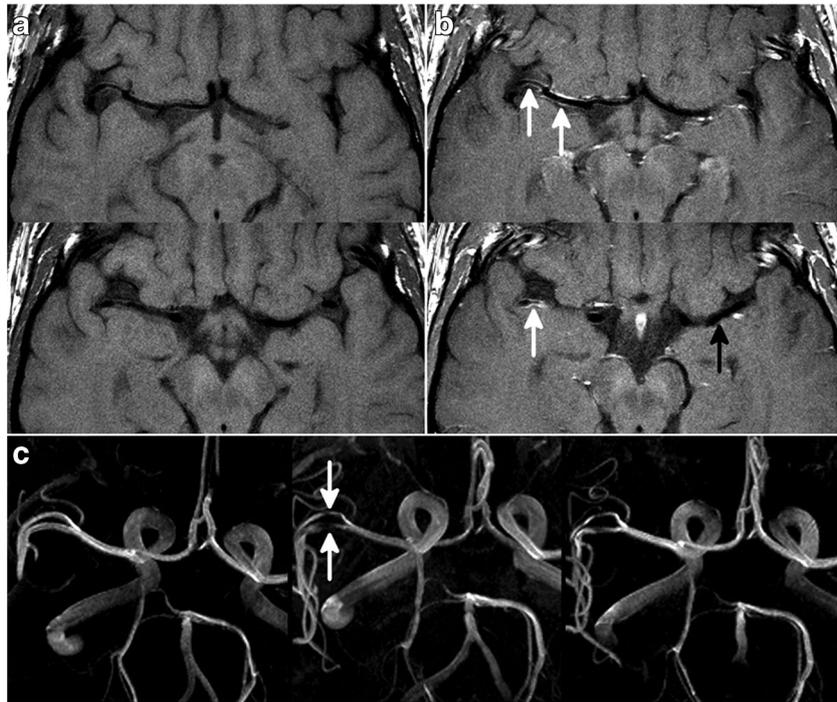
Central nervous system vasculitis. Reprinted with permission from Mandell et al., American Heart Association [63]. “Axial T1-weighted vessel wall MRI pre-gadolinium (a) and post-gadolinium (b) at presentation demonstrates arterial wall thickening and enhancement (arrows). MR angiogram at the time of vessel wall imaging (middle image in c) shows narrowing of the right middle cerebral artery (arrows) compared with an MR angiogram obtained 2 months earlier (left image in c). Follow-up angiogram 3 months after vessel wall MRI (right image in c) shows persistent narrowing.”
